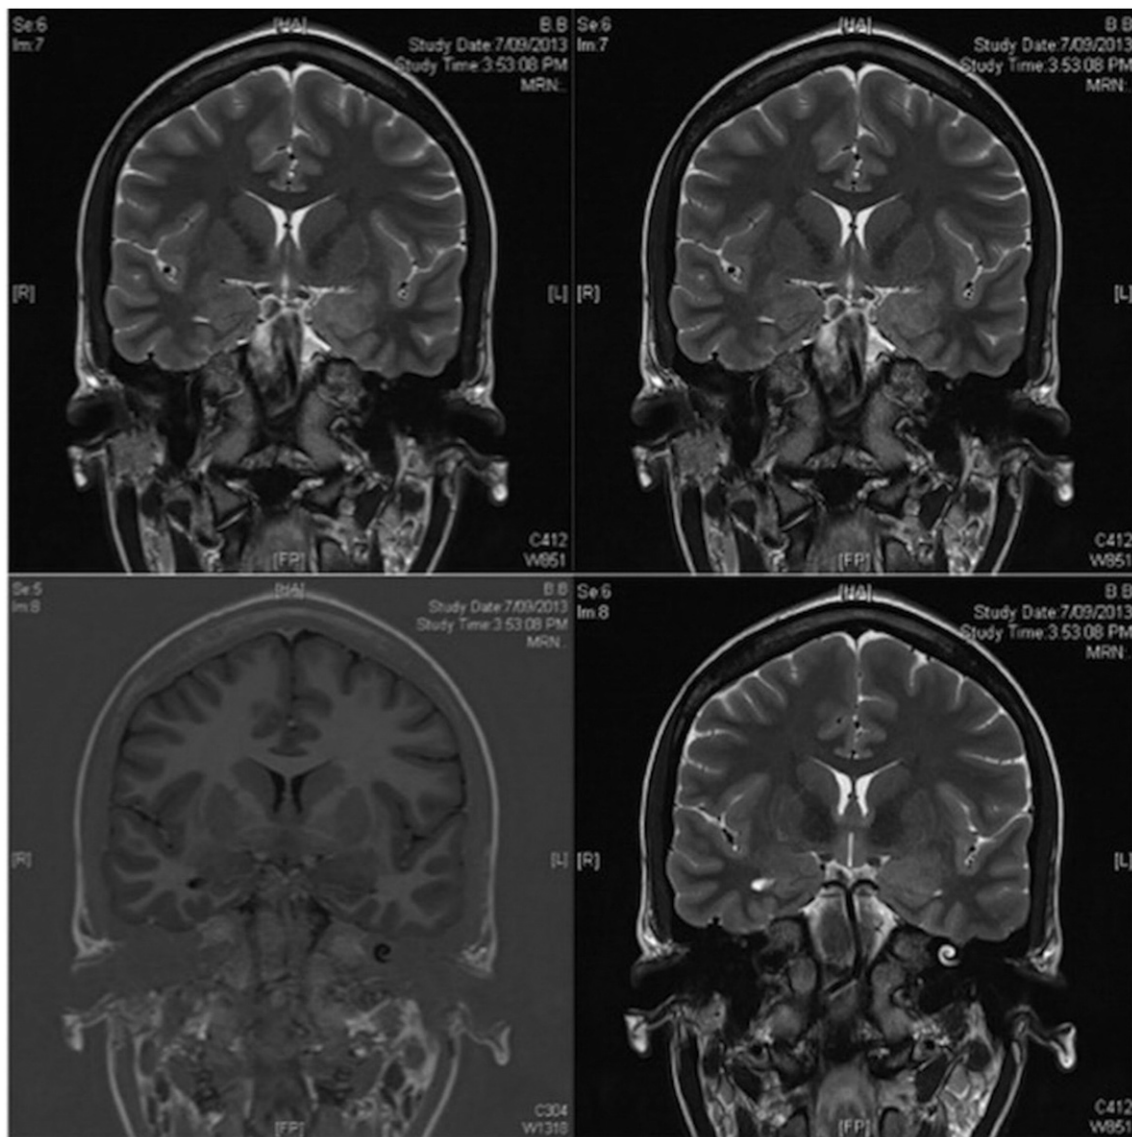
Magnetic resonance imaging study demonstrating left-sided amygdala enlargement.
